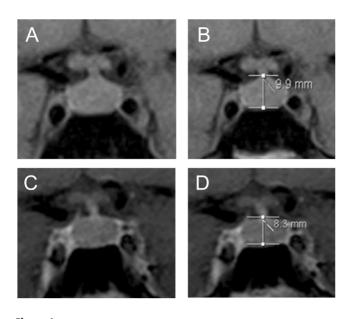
Coronal MRI pre- (A,B) and post-pancreatic (C,D) surgery showing shrinkage of the pituitary gland following surgery.
